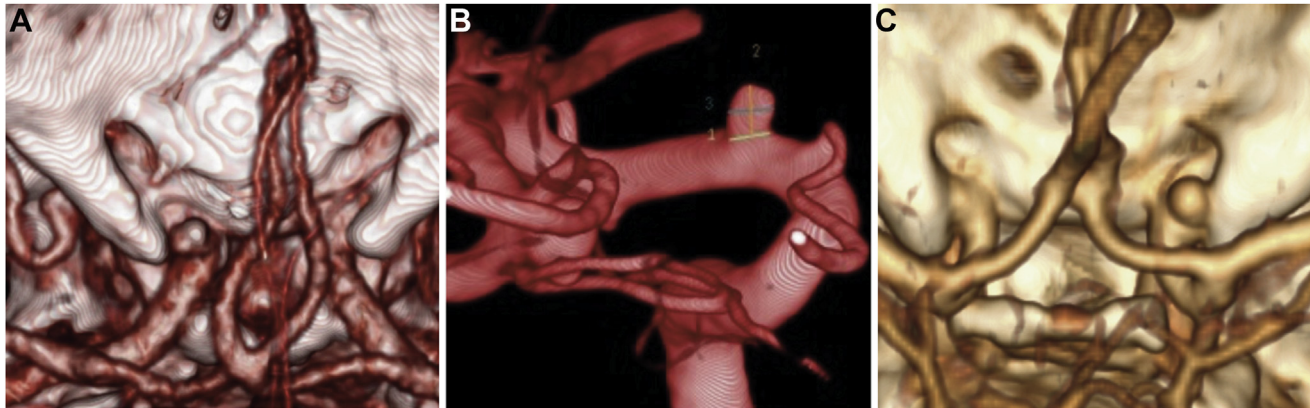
(A) Preoperative computed tomography angiographic reconstruction of patient 1 showing a left superior carotid–ophthalmic aneurysm (aspect ratio [AR], 1.25). (B) Preoperative digital subtraction angiogram of patient 2 showing 2 right carotid aneurysms: a superior carotid–ophthalmic and medial cerebral artery aneurysm (AR, 2.3). (C) Preoperative computed tomography angiographic reconstruction of patient 3 showing a right superior carotid–ophthalmic aneurysm (AR, 1.5).
